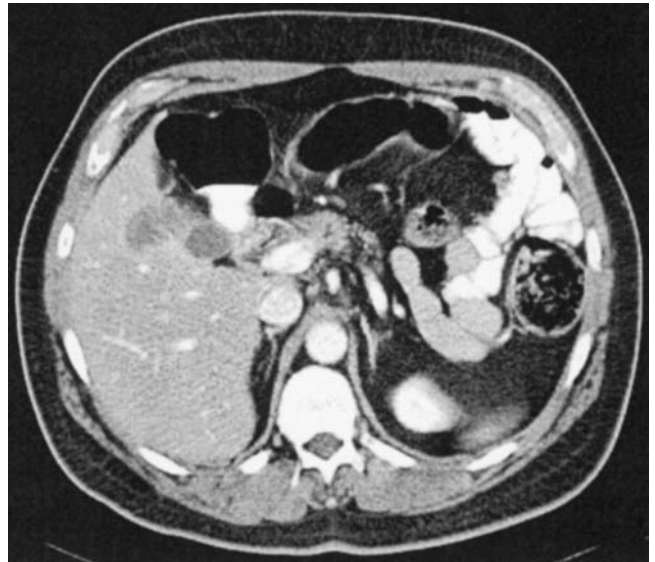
CT scan of gallbladder cancer. The image shows a 3.5×4 cm lesion arising from the gallbladder fundus and extending into segment 5 of the liver.
